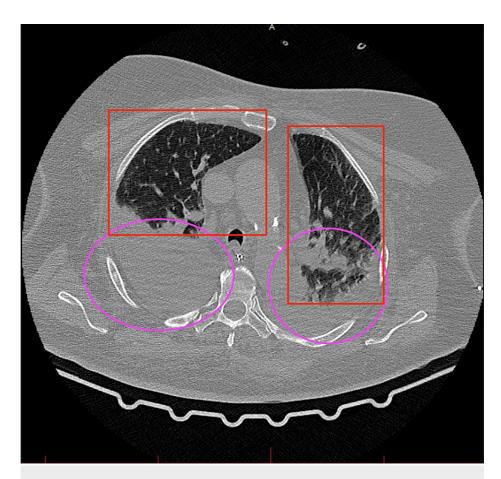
CT scan of the lungs. Lower pulmonary lobes
